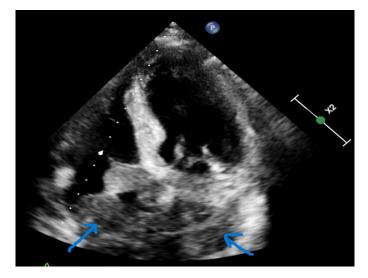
Apical four-chamber view on transthoracic echocardiography. In the marked areas, a mass spreading from the interatrial septum to both the right and left atrium is observed.
